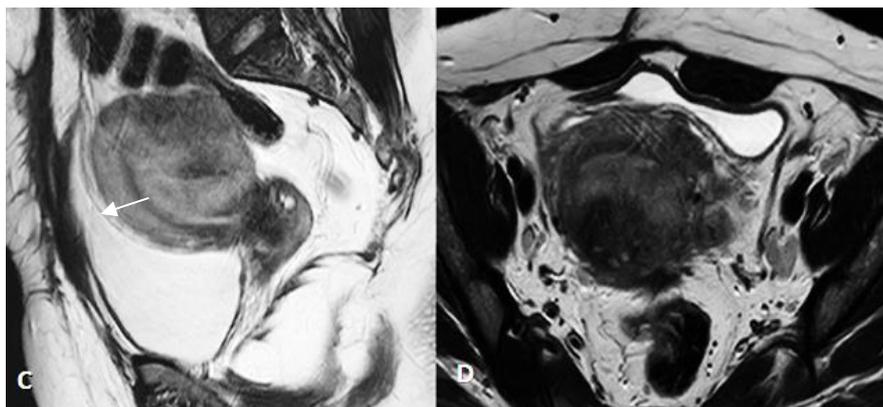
(C) (D) In the same patient MRI-pelvis T2 sagittal & axial image shows a well-defined T2 heterogeneous hypointense lesion in the fundal region and posterior myometrium indenting endometrium anteriorly intramural fibroid. HPE proved to be the same.
